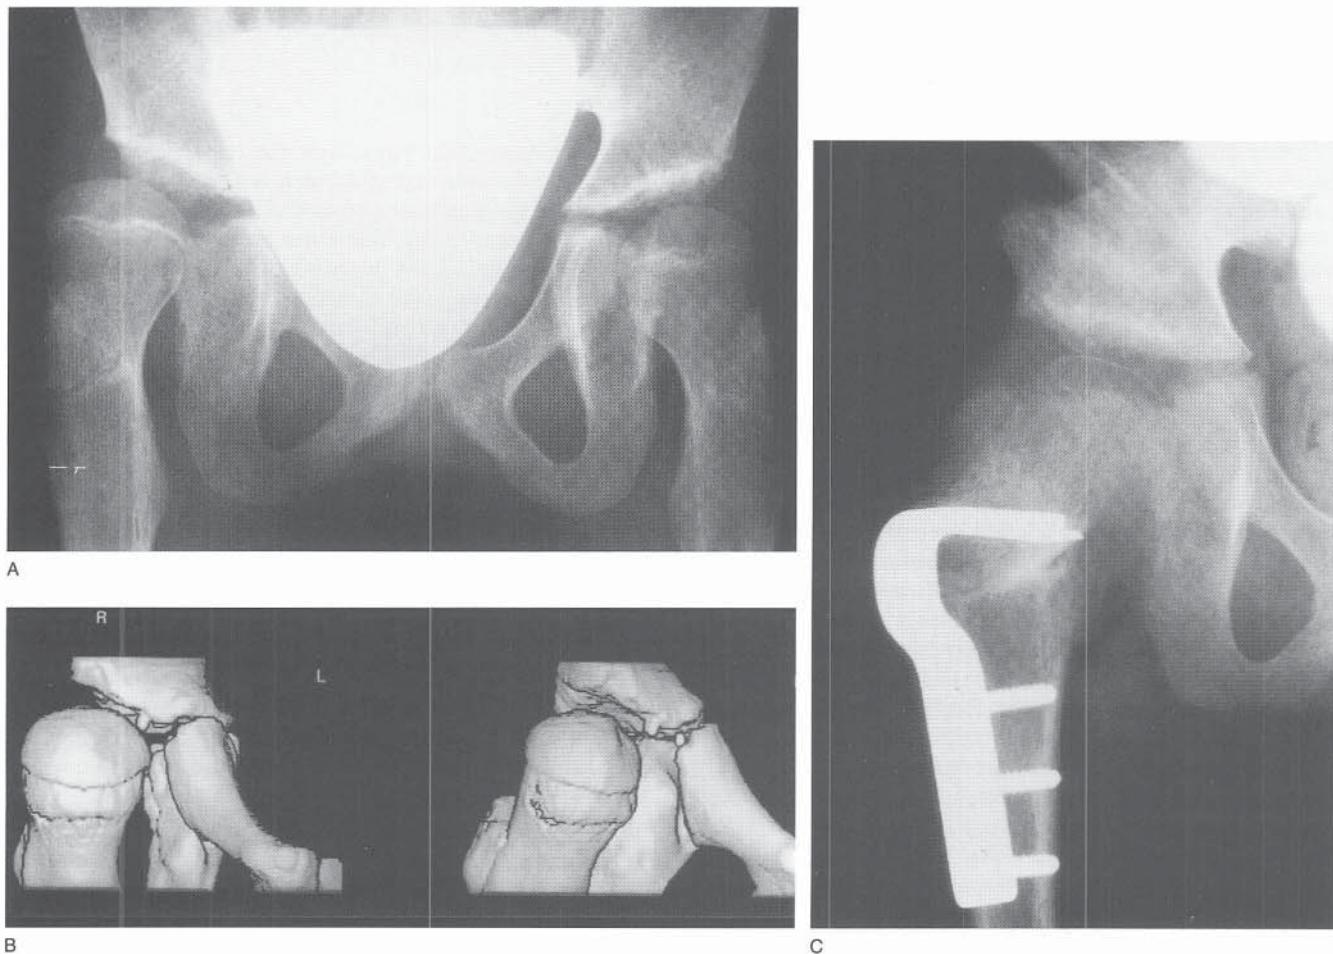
A, AP radiograph of the pelvis in a 10-year-old child with cerebral palsy. B, A three-dimensional CT scan of the right hip reveals global deficiency of the acetabulum, with anterior, superior, and lateral lack of coverage. C, The hip was reconstructed by muscle release, femoral varus derotation osteotomy with blade-plate fixation, and a Dega pelvic osteotomy.
